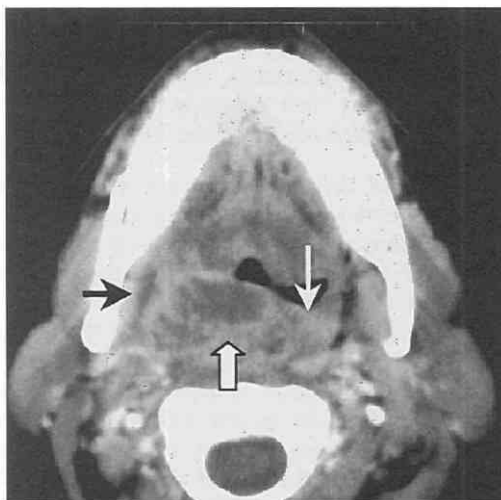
Retropharyngeal infection. Axial contrast-enhanced CT scan through the oropharynx demonstrates enhancing, thickened retropharyngeal soft tissue consistent with cellulitis (thin white arrow) and a low attenuation collection on the right suggesting abscess formation (thick white arrow) that causes significant airway compromise. Note the abscess starting at the region of the lateral retropharyngeal lymph node (of Rouviere). Associated inflammation results in increased attenuation of the prestyloid parapharyngeal fat on the right (black arrow).
